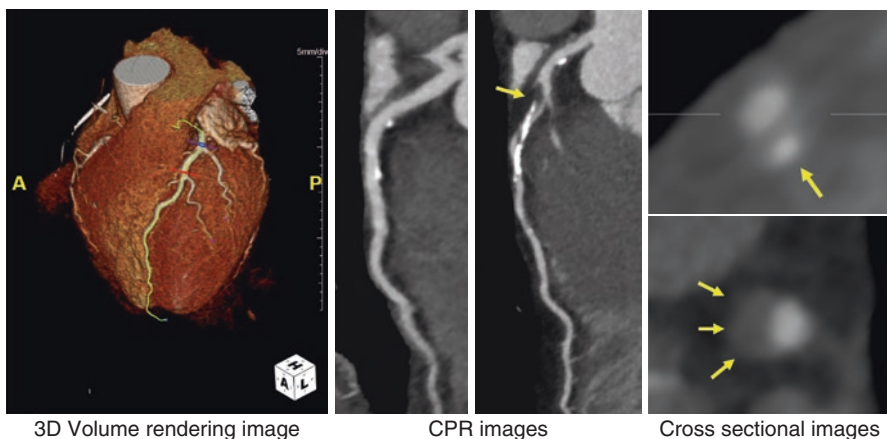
Coronary CT analysis with volume rendering 3D, curved planar reformatted images (CPR), and cross-sectional images are shown. Left shows 3D volume rendering image for whole heart. Middle-left shows CPR for RCA with minimum coronary atherosclerosis. Middle-right shows severe atherosclerosis with obstructive proximal LAD. Right upper and lower show cross-sectional view images for high-risk plaque feature. Upper shows calcified vessel with internal low attenuation plaque (napkin ring like), and lower shows positive remodeling, lipid rich plaque (attenuation lower than 50HU), and spotty calcification
